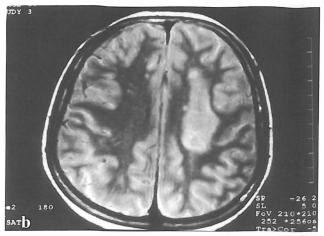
(a-b): PML (progressive multifocal leukoencephalo pathy); Axial proton density MR images of an HIV sero-positive patient show leukodystrophic plaques in periventricular and subcortical deep white matter with no mass effect.
